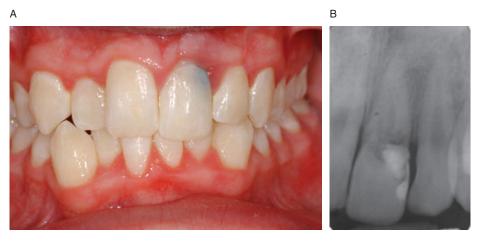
A, Patient's condition at initial appointment. B, Initial periapical radiograph of the tooth with internal resorption.
